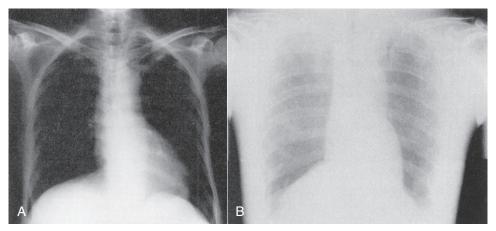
A, Overexposed radiograph of the chest is too black to be diagnostic. B, Likewise, an underexposed chest radiograph is unacceptable because no detail to the lung fields is apparent. (Courtesy Richard Bayless, University of Montana.)
